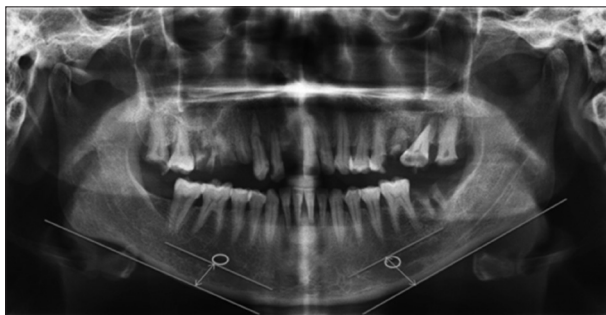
Orthopantomogram showing vertical measurement from the tangential line drawn to the lower border of the mental foramen to a tangential line drawn to basal bone of mandible on the right side along with vertical measurement from a tangential line drawn to the upper border of the mental foramen to a tangential line drawn to basal bone of mandible on left side
